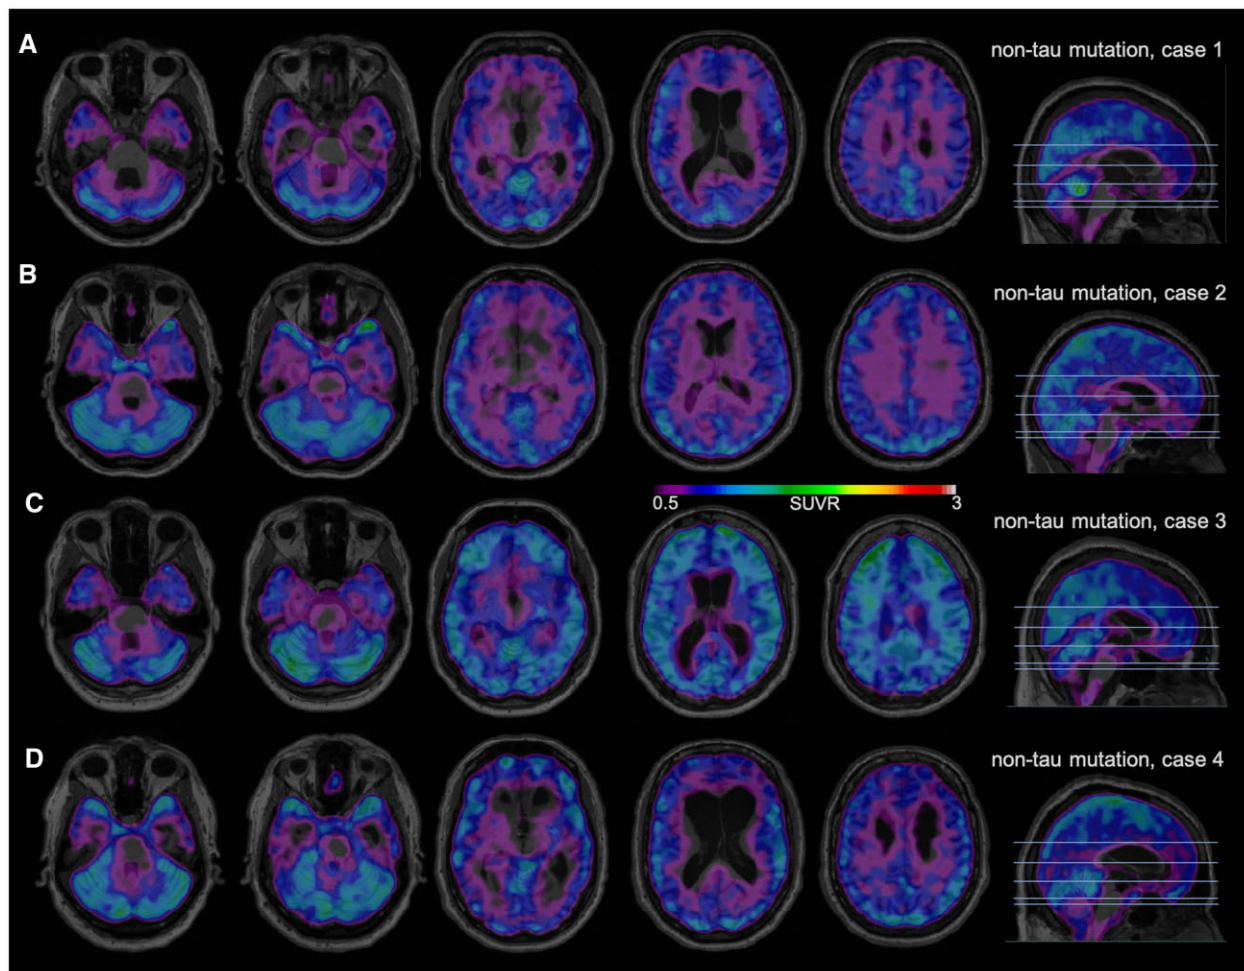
^{18}F -MK-6240 tau-PET scans in symptomatic non-tau mutation subjects. A higher SUVR represents stronger binding. Binding to meninges, including the tentorium cerebelli, is considered to be off-target. Scans are masked to minimize off-target binding to meninges. (A) A 51-year-old male with bvFTD/svPPA due to VCP mutation, FTL D-CDR 0.5, MMSE 23/25. (B) A 41-year-old male with bvFTD due to C9orf72 mutation, FTL D-CDR 0.5, MMSE 27/30. (C) A 44-year-old male with bvFTD due to C9orf72 mutation, FTL D-CDR 2, MMSE 12/30. (D) A 61-year-old male with bvFTD due to GRN mutation, FTL D-CDR 1, MMSE 19/30.
